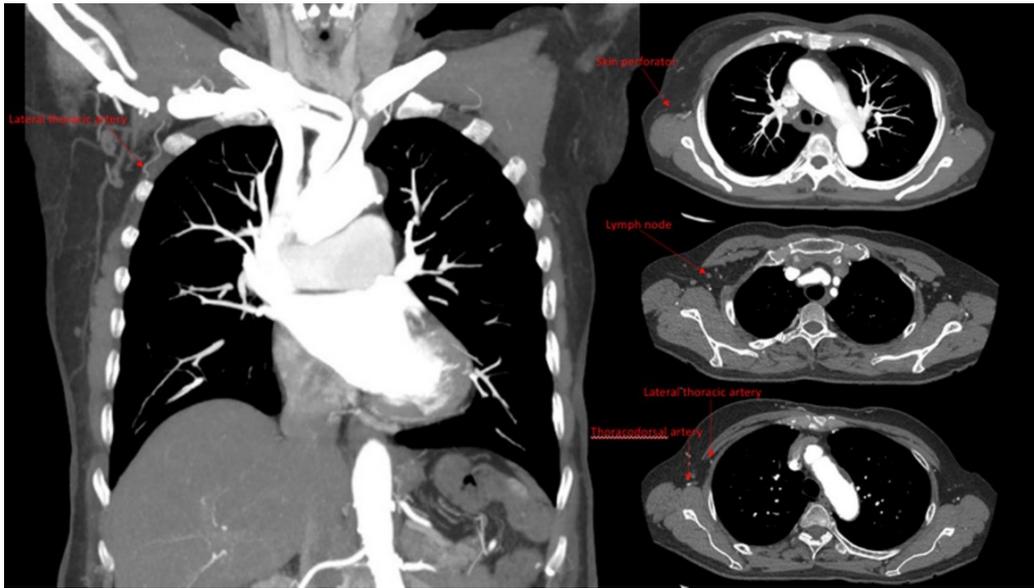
Thoracic computed tomography angiography (CTA) of the right lateral thoracic artery (LTA).
